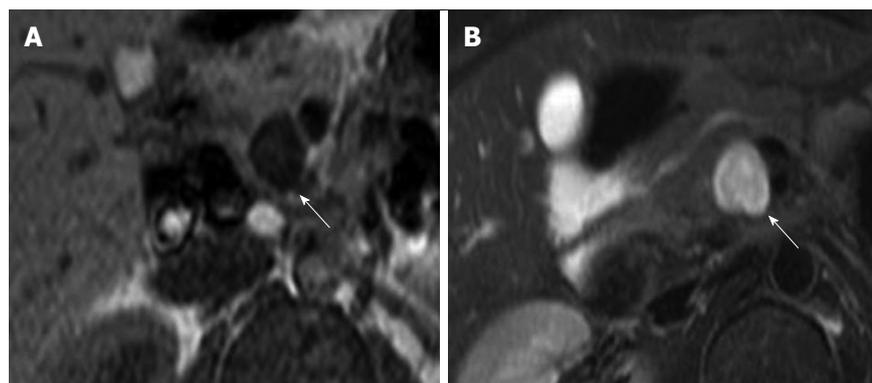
Magnetic resonance imaging of Case 1 showed a round mass (arrows) with low signal intensity in T1-weighted images and high signal intensity in T2-weighted images. The tumor signal was uniform. A: T1-weighted image; B: T2-weighted image.
